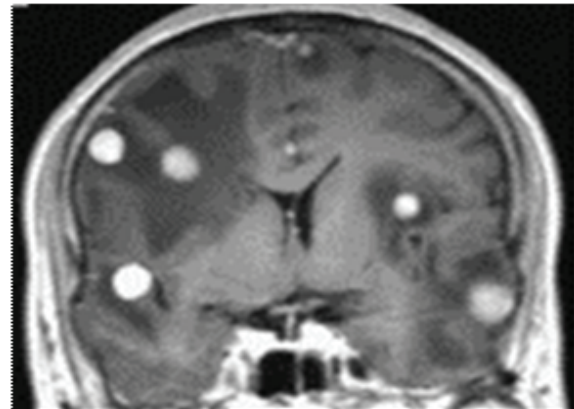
MRI of brain metastasis –before (up) & 1½ months after treatment (down).
